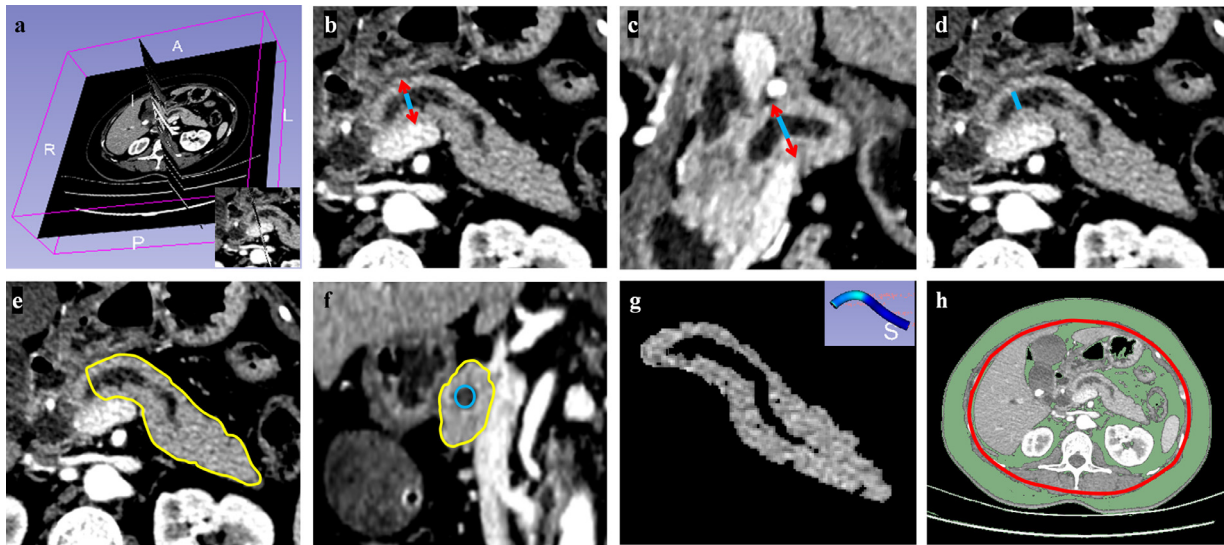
Representative preoperative CT images of segmentations and morphologic depictions of pancreatic remnant: (a) estimated transection line in 3D-Slicer; (b) transverse section for measuring pancreatic thickness (red arrow), subtracting diameter of main pancreatic duct (MPD, blue line) from parenchymal thickness for final figure and evaluating pancreatic atrophy by MPD-to-pancreatic thickness ratio ($MPD / [thickness - MPD]$) described in Table S2; (c) coronal section for measuring full pancreatic width (red arrow), subtracting MPD diameter (blue line) for final figure; (d) transverse section for measuring MPD diameter (blue line) for 0–4 scoring of Fistula Risk Score (FRS) as calculated in Table S4; (e) surface area encircled by yellow lines, indicating full pancreatic remnant; (f) Full pancreatic stump area (encircled by yellow lines) calculated by subtracting the visible MPD area from entire area of stump; (g) estimate of pancreatic remnant volume using Otsu's thresholding method (>25 HU) for automated subtraction of MPD volume from full pancreatic remnant volume by segmentation, the mean attenuation represented by mean HU value of all pixels within volume; and (h) assessment of visceral fat area (VFA).
